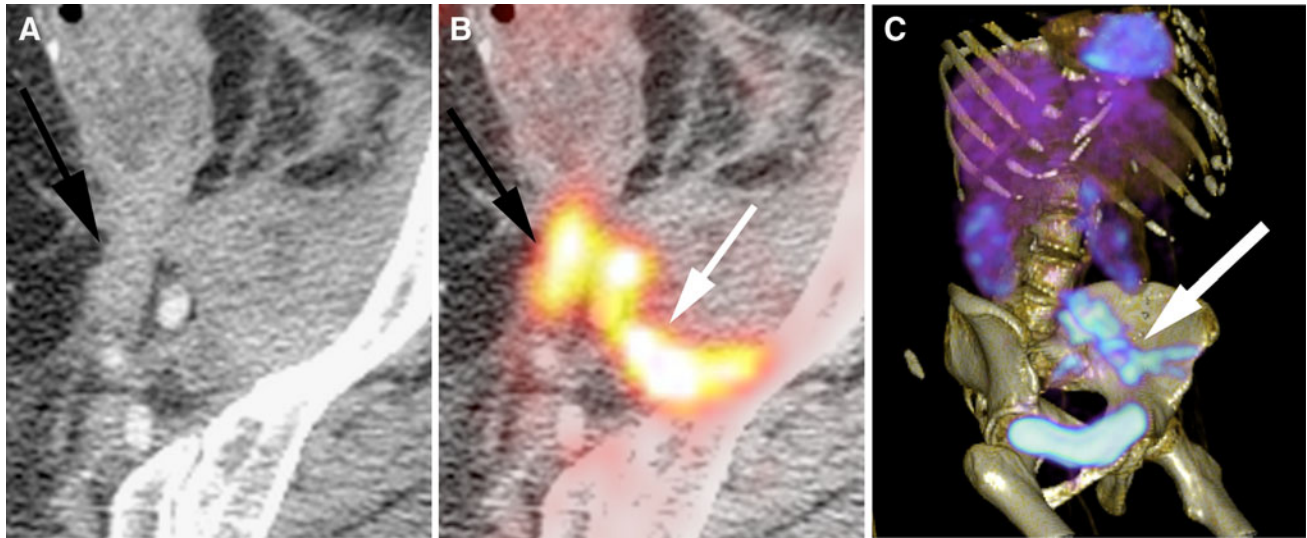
The CT enterography portion (A) of this combined PET/CTE scan demonstrates mural thickening, mucosal enhancement in a stratified pattern (*arrow*), and mild hyperemia of the vasa recta with fibrofatty proliferation. The PET portion (B) of the PET/CTE scan confirms active inflammation based on intense  $^{18}\text{F}$ -FDG uptake in this small bowel segment.
